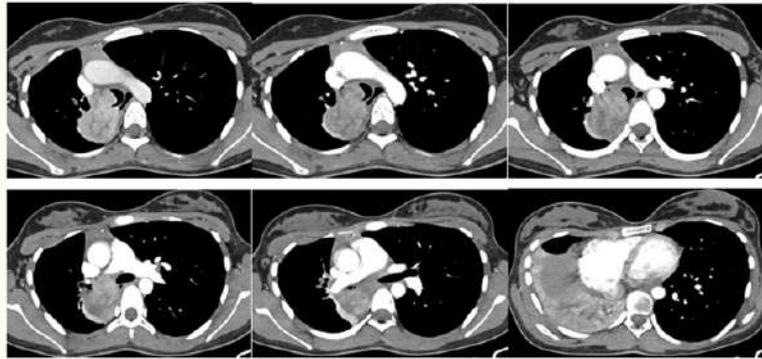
Axial (A-F) Contrast enhanced Computed Tomography images show well defined multi-lobulated heterogeneously enhancing lesion in the distal trachea, carina extending to the right lower lobe bronchus with significant extraluminal component causing abrupt cut off of the bronchus intermedius, causing middle lobe & lower lobe consolidation collapse.
